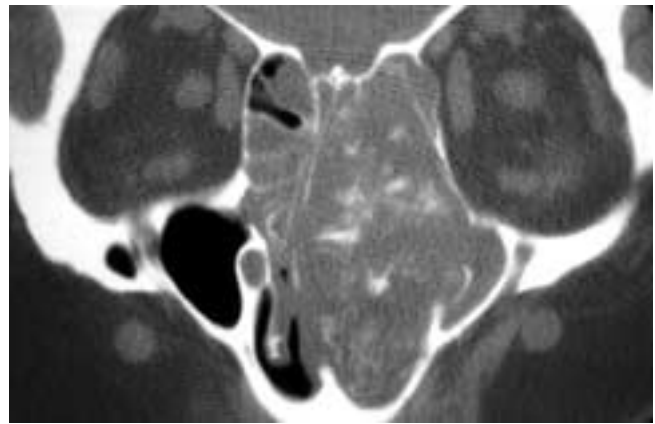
Coronal CT scan shows a destructive mass in the nasal cavity and ethmoid sinuses, sphenoid sinuses, and right maxillary sinus. The tumor erodes the central skull base and the floor of the anterior cranial fossa. Within the mass are irregular areas of calcification or ossification. This appearance is highly suggestive of a sarcoma rather than a carcinoma. This patient had an osteogenic sarcoma.
